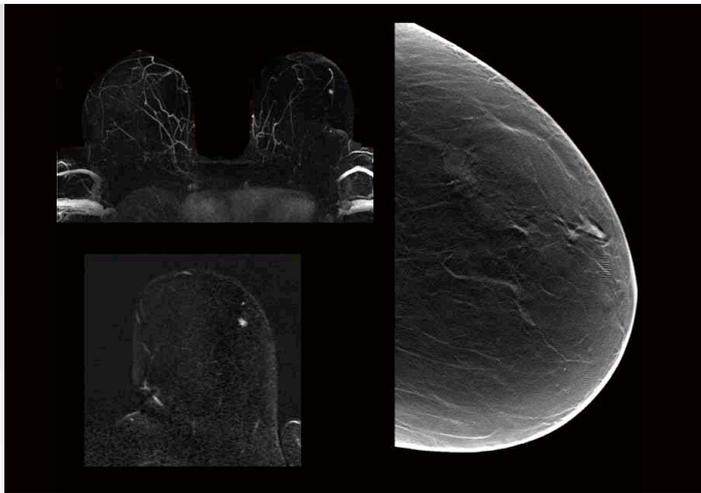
MIP and subtraction after contrast agent application (left) show early and strong enhancement of the small lesion on the left side; in addition, the broad vessel in the surrounding tissue is visible in correlation to power Doppler (see Fig. 5); tomosynthesis shows the morphology of the lesion (right) particularly well.
